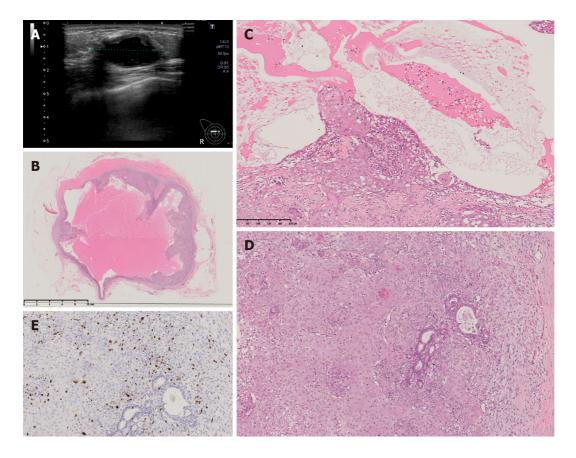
Imaging and pathology findings at first recurrence. A: Ultrasonography showed a well-defined, oval, low-isoechoic mass; B: The tumor was a cystic lesion, and the cystic wall had nodules or irregular thickening. The cysts contained mucus (x 32 magnification); C and D: Epithelium with squamous metaplasia growing into the lumenal side (C: × 100 magnification, lumen side) and (D: × 100, membrane side). Dense growth of spindle-shaped myoepithelium is found on the side of the membrane. The myoepithelium spreads underneath the existing glandular epithelium. Tumor cells show prominent nuclear atypia and high mitotic counts; E: The Ki 67 hot spot is 57.1% (x 100 magnification, Ki67).
